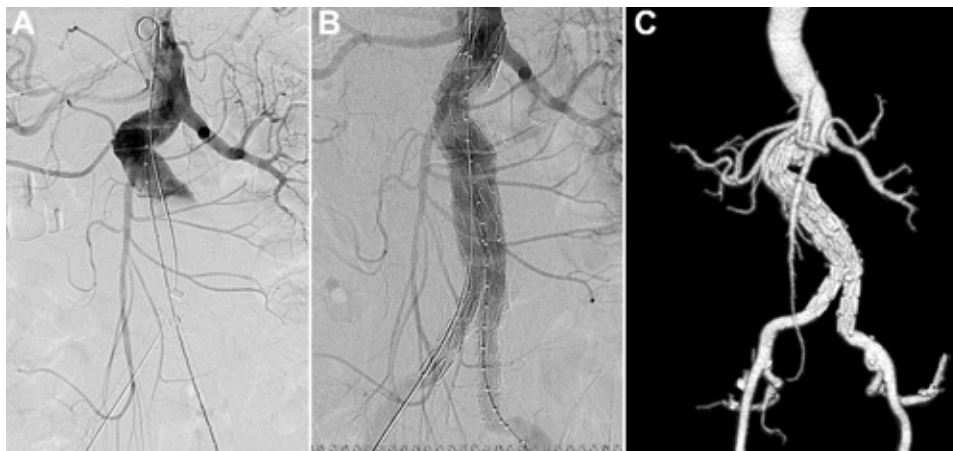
♦ Example of hostile neck anatomy in a 65-year-old patient with a 68-mm AAA. (A) Intraoperative angiography shows a double kinked aneurysm neck with a 60° angle at the left renal artery and a 90° bend in the middle of the neck. (B) The completion angiogram demonstrates exclusion of the aneurysm and a moderate straightening of the 2 kinks by the flexible stent-graft. (C) CT reconstruction at 3 months shows the unchanged position of the stent-graft and sustained exclusion of the AAA.
